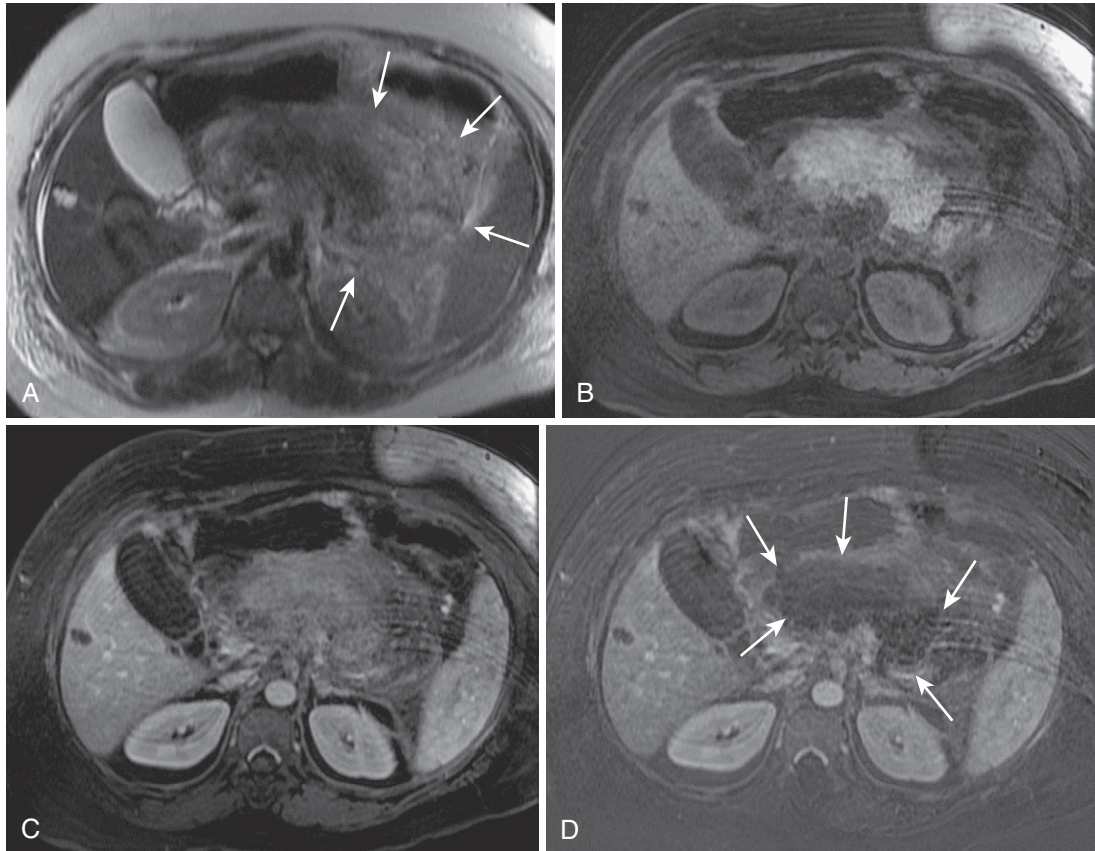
Pancreatic necrosis. A, The heavily T2-weighted image shows extensive peripancreatic inflammation (*arrows*) surrounding an ill-defined pancreatic body and neck with relative hypointensity in the setting of acute inflammation. B, Marked parenchymal hyperintensity on the fat-suppressed T1-weighted image signifies hemorrhage. The relative hypointensity on the postcontrast image (C) reflects the preferential enhancement of surrounding structures, and the pancreatic signal void (*arrows*) on the subtracted image (D) confirms necrosis.
